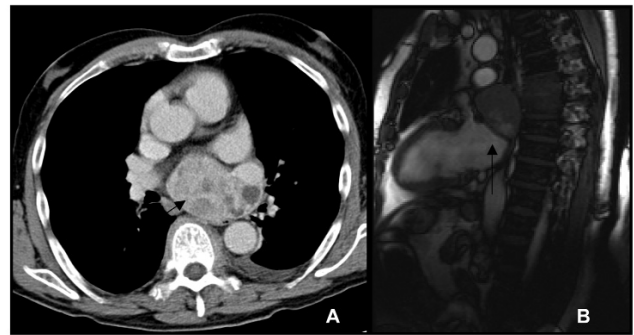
A, Thoracic multislice computed tomography showing a heterogenic retrocardiac mass in contact with the left atrium and the descending aorta. B, Lateral projection of the mediastinum by magnetic resonance imaging. The left atrium is compressed by the tumor.
